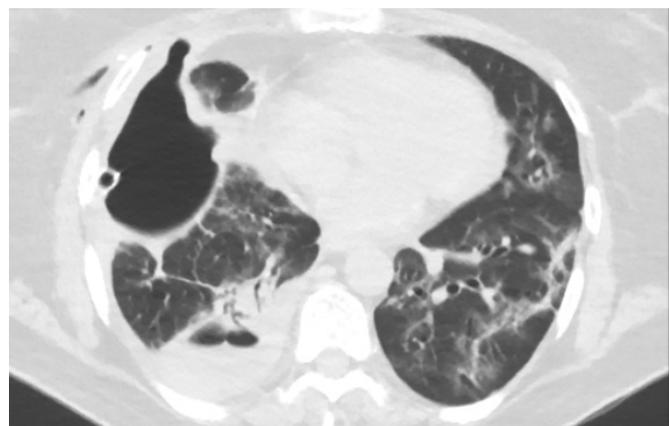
Pneumothorax and chest tube is seen at CT.
